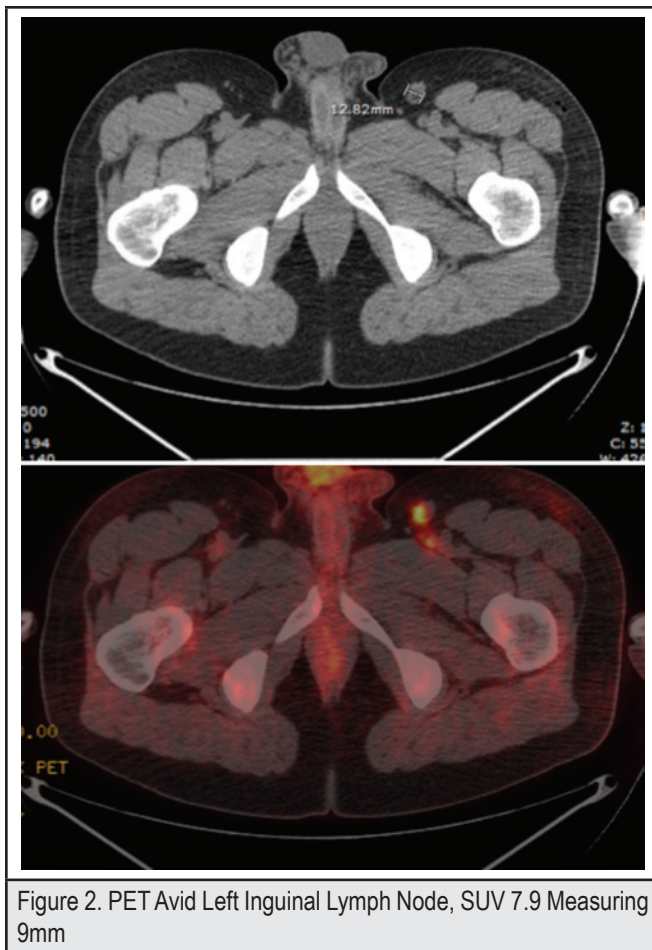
PET Avid Left Inguinal Lymph Node, SUV 7.9 Measuring 9mm
